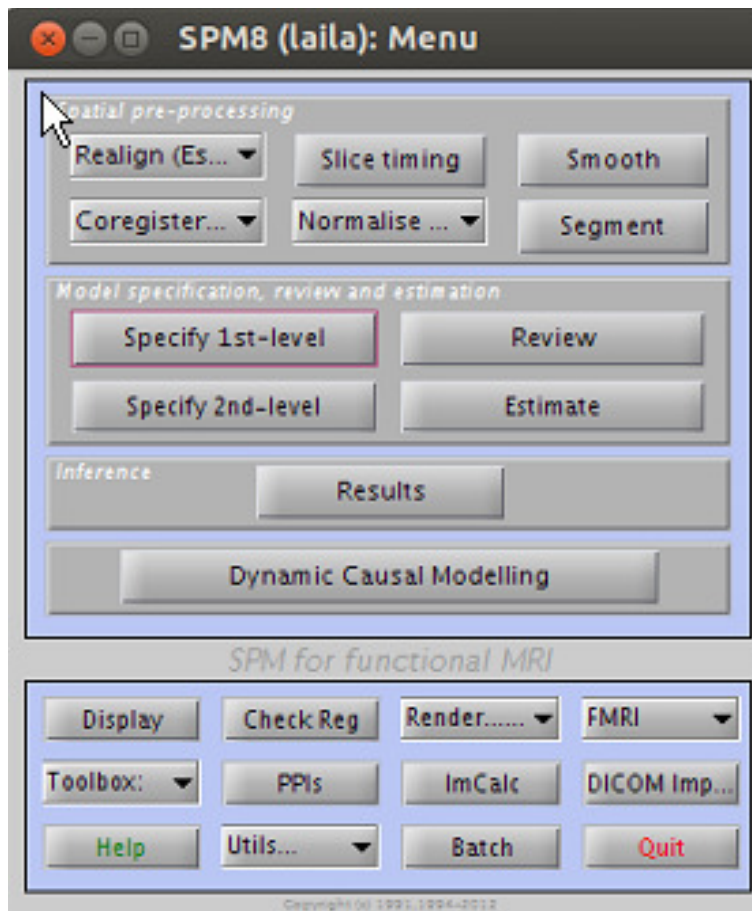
The main window of SPM8 for analyzing MRI images.
